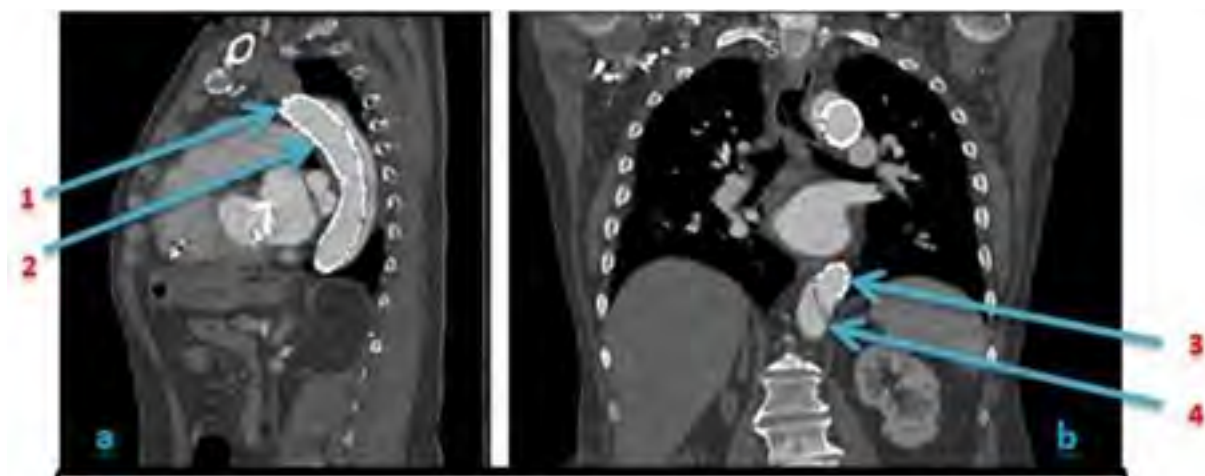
CT scan of the chest with contrast for evaluation after TEVAR; a) Sagittal view, b) Coronal view. 1= Proximal end of the stent, 2= Middle of the stent, 3= Distal end of the stent, 4= Distal dissected area with no reentry.
